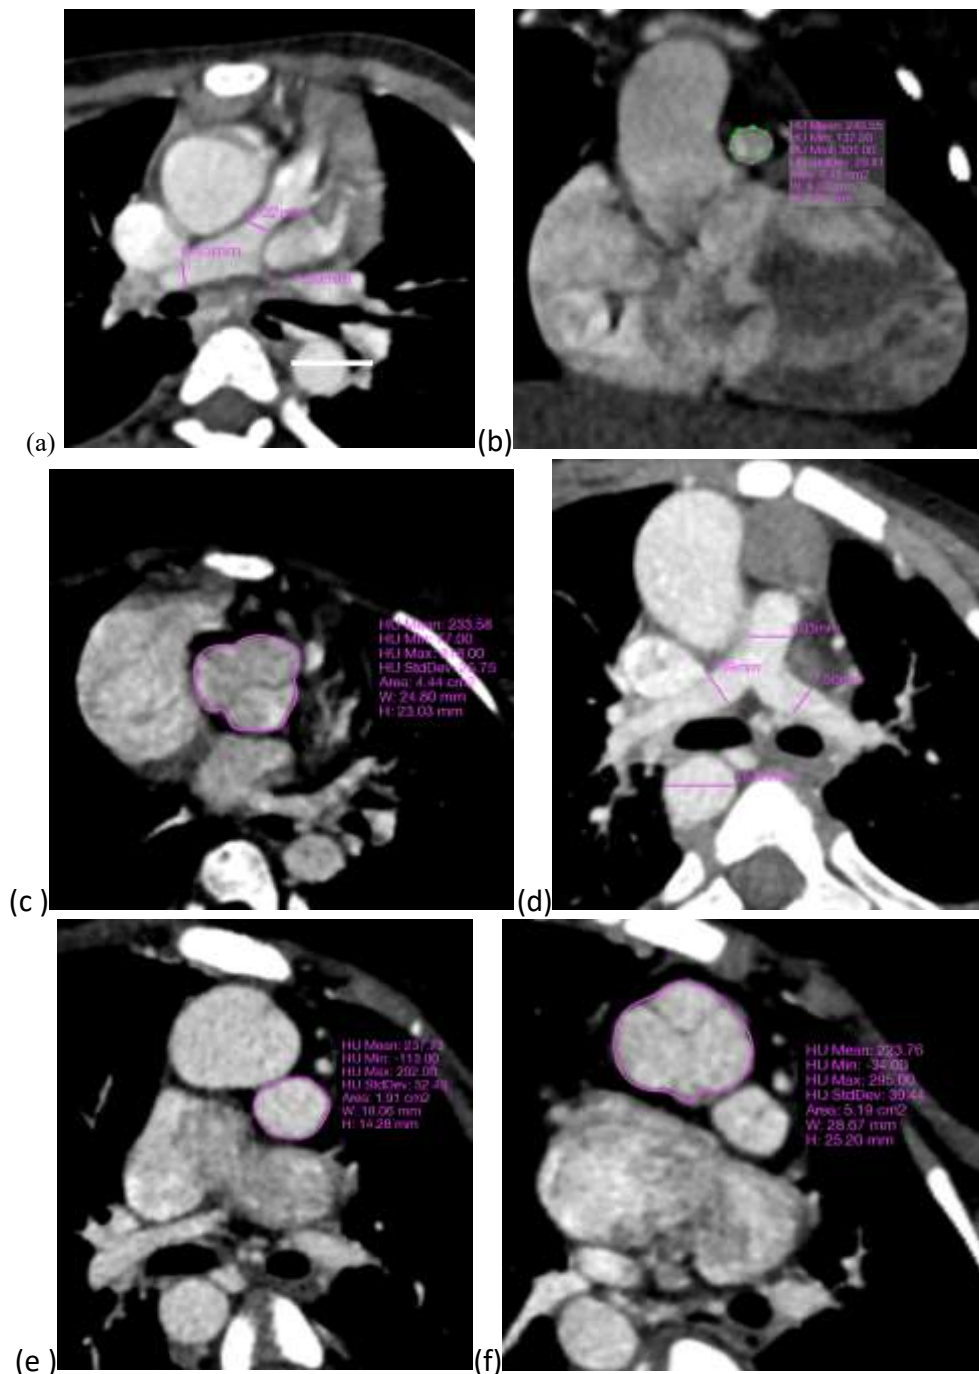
Representative preoperative cardiac CT morphometry in TOF according to subsequent surgical repair strategy. (A–C) TAP case: (A) MPA, RPA, LPA, and descending thoracic aortic measurements, with marked LPA narrowing; (B) en-face pulmonary valve annulus demonstrating a minimum diameter of 7.31 mm and area of 0.45 cm²; and (C) en-face aortic annulus demonstrating a minimum diameter of 23.03 mm, yielding a PV/Ao Dmin ratio of 0.32. (D–F) Non-TAP case with right-sided aortic arch: (D) MPA, RPA, LPA, and descending thoracic aortic measurements, with a MAPCA arising from the descending thoracic aorta; (E) en-face pulmonary valve annulus demonstrating a minimum diameter of 14.28 mm and area of 1.91 cm²; and (F) en-face aortic annulus demonstrating a minimum diameter of 25.20 mm, yielding a PV/Ao Dmin ratio of 0.57.
